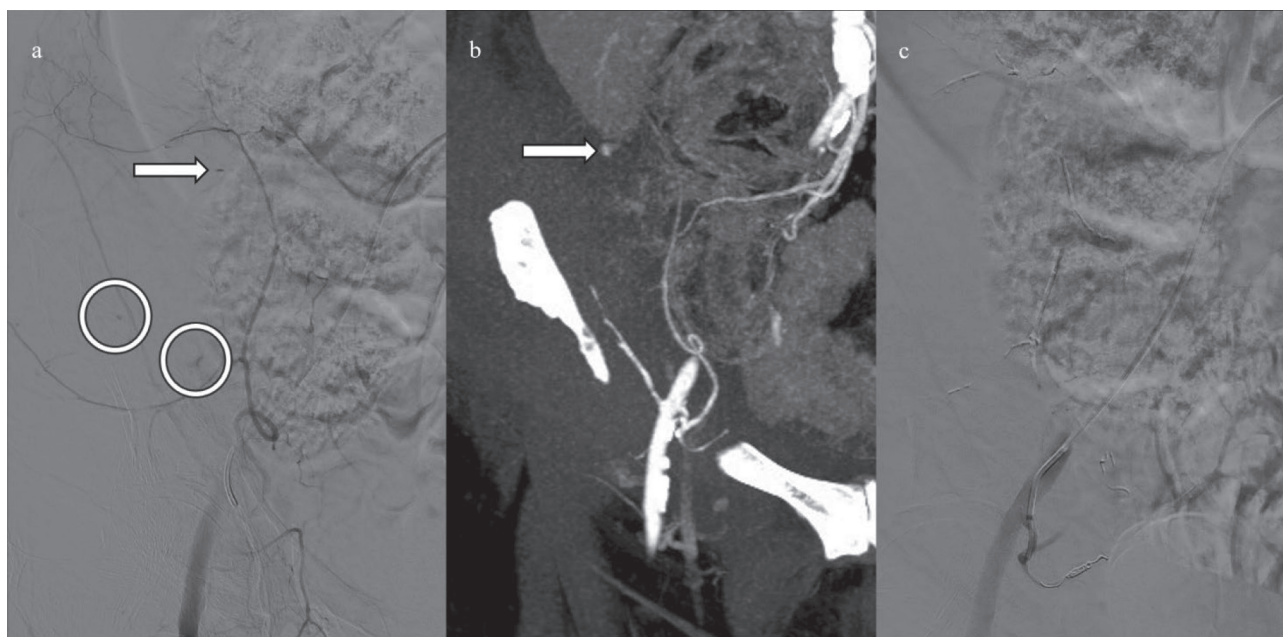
Transarterial embolization of the right rectus sheath hematoma. (a) Selective DSA from the right inferior epigastric artery which confirmed the presence of multiple active arterial blushes (circles), one of the bleeding spots, matched the CT findings (arrow). (b) Magnification of the pre-procedural coronal CT MIP reconstruction image showing active bleeding (arrow) matching the DSA findings. (c) DSA after glue and coils embolization of the right inferior epigastric artery showing complete devascularization.
